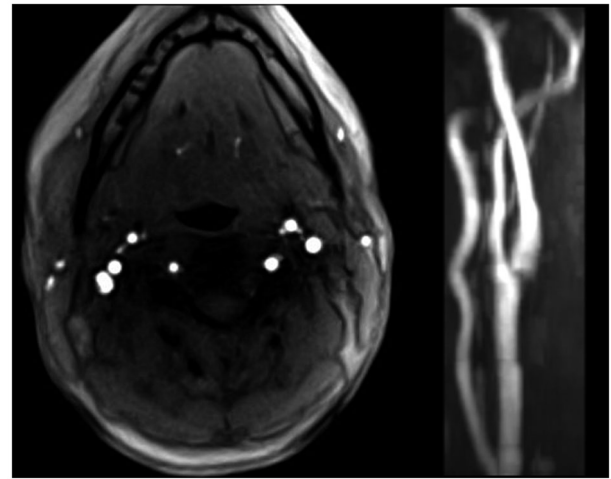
Selected T_1 -weighted image of a 6.4-second real-time MRI acquisition (128-mm volume) and corresponding maximum intensity projection covering the carotid arteries (single side) of a healthy subject at 40.0 ms and $0.8 \times 0.8 \times 4.0 \text{ mm}^3$ resolution. For details, see Table 1
